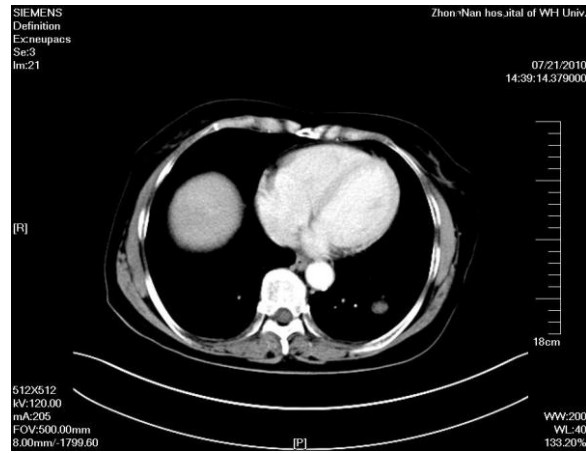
Contrast enhanced CT scan shows mild enhancement of the nodule.
